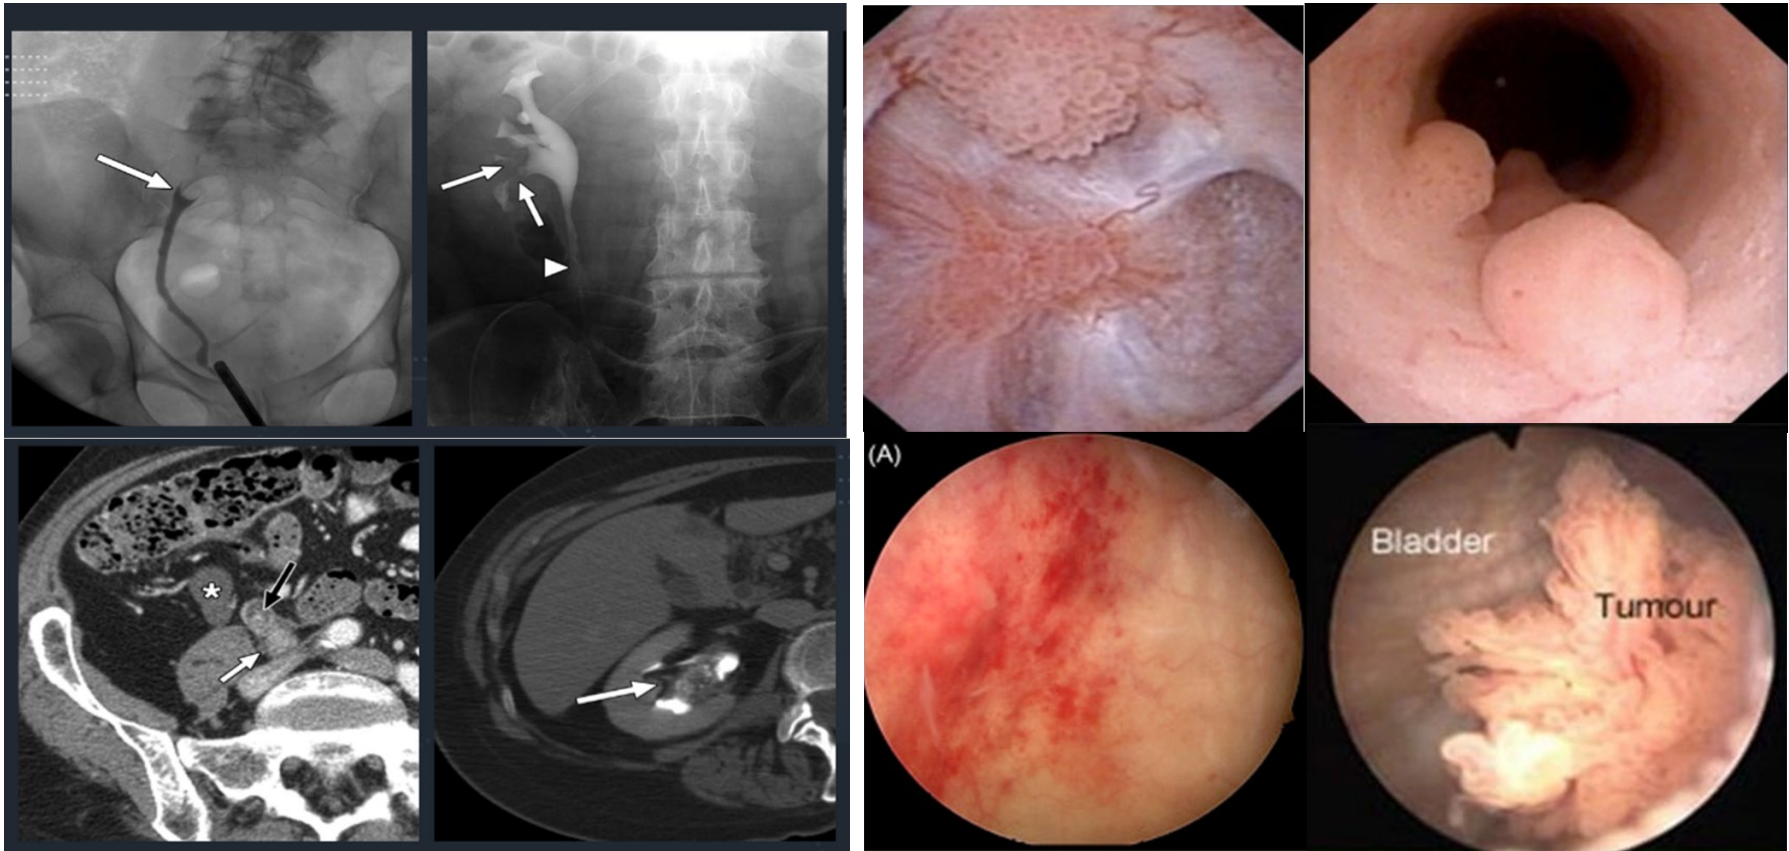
Radiograph and CT depiction of 'filling defects'.
